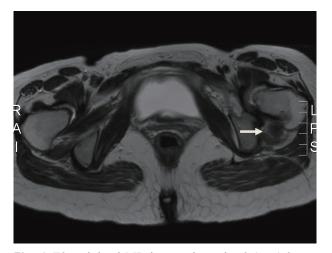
T2-weighted MR image showed a 2.1 x 1.8 cm, irregular signal intensity soft tissue nodule adjacent to or overlapping a tendon of the quadratus femoris (arrow). Signal intensity over periphery zone of the nodule is lower than that muscle. Apparent irregular lower signal intensity is seen at central zone of nodule suggesting hemosiderin collection.
